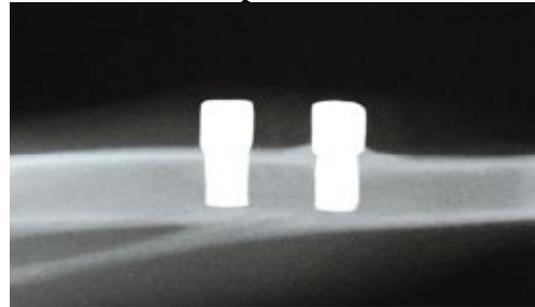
Conventional radiographic view of Ti implant coated with HA by dipping method for 6 weeks duration shows cortical bone bounded the implant coronal portion and radiopaque field around the implant (C) uncoated and (HA) coated with hydroxyapatite by EPD method.
